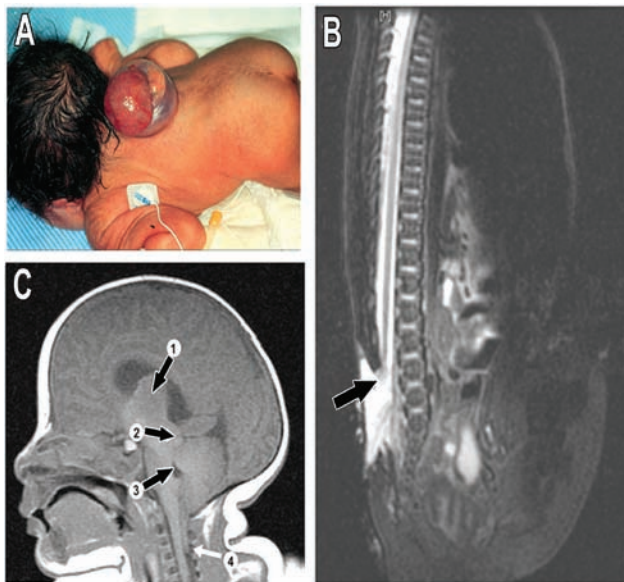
Images showing: A) newborn with thoracic myelomeningocele. The diaphanous sac is filled with CSF and contains fragile vessels in its membrane. A placode-containing remnants of the nervous system can be seen in the lower half of the lesion; B) a one-day-old neonate with myelomeningocele at the lumbar region. A T2-weighted MRI image with fat saturation showing low-lying spinal cord tethered to the upper end of spina bifida (arrow); C) sagittal brain MRI image shows features of Chiari II malformation. There is small-sized posterior fossa, downward herniation of the cerebellar tonsils, through the foramen magnum (4), deformed shape of the fourth ventricle (3), tectal beaking (2); and prominent massa intermedia (1).
